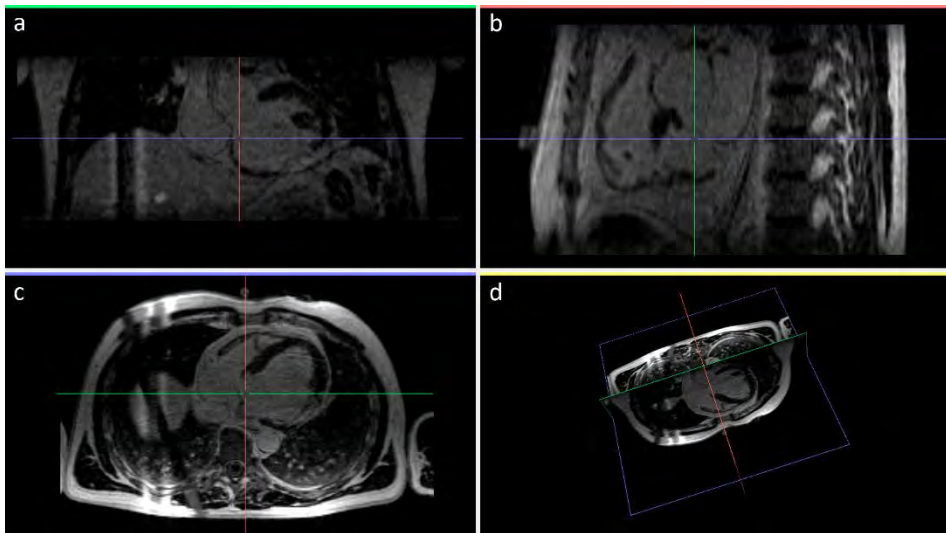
Cardiac DE-MRI stack. Views of DE-MRI slices in standard planes: (a) coronal, (b) sagittal and (c) axial planes and (d) 3D view of orthogonal standard planes.
